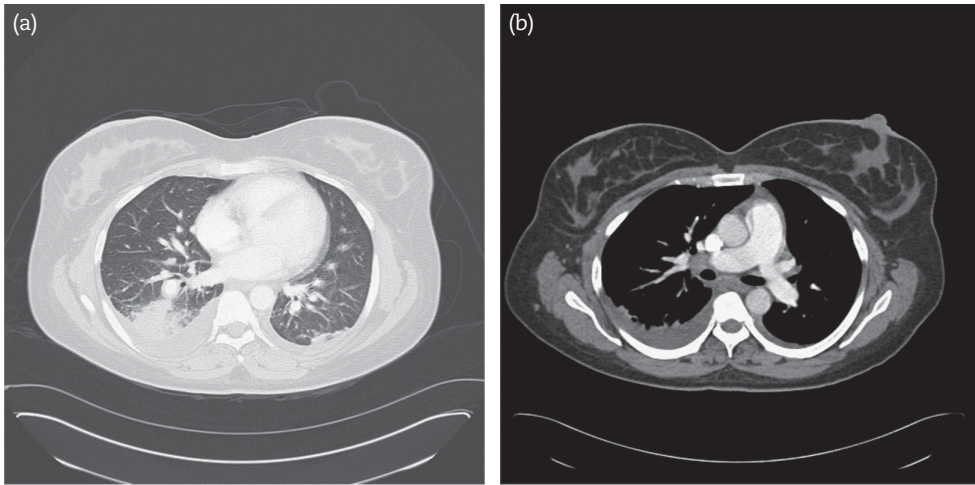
Chest CT imaging, a. Lung windows showing right lower lobe consolidation with several patchy areas of focal airspace disease in the left lower lobe and associated bilateral effusions. b. Mediastinal windows showing a conglomeration of several enlarged subcarinal lymph nodes (2.6×1.8 cm).
